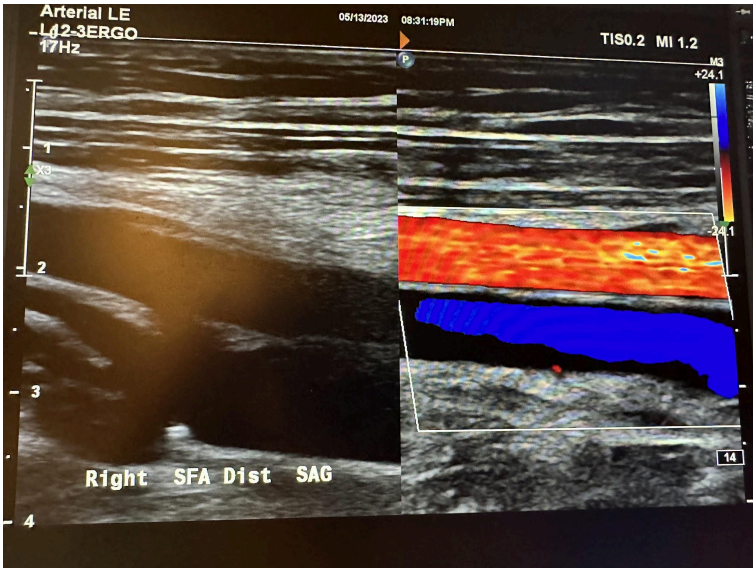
Sagittal images of the right distal superficial femoral artery without color Doppler and with color Doppler.
